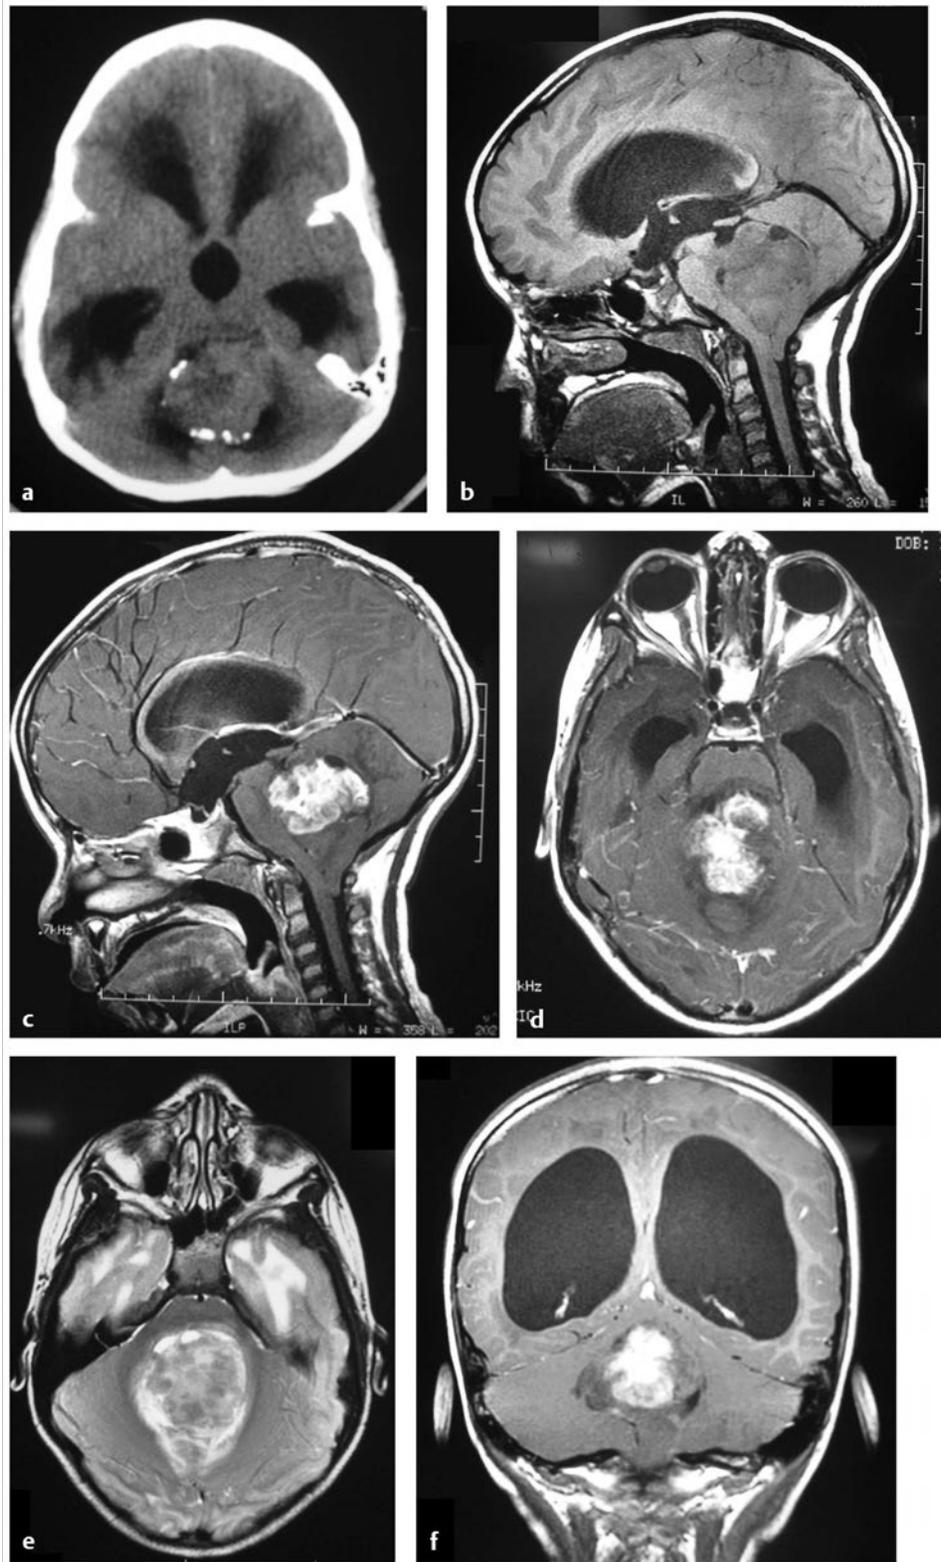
A 5-year-old with headaches and vomiting. (a) An unenhanced computed tomography (CT) scan shows a posterior fossa tumor, with some peripheral calcifications. There is associated supratentorial noncommunicating hydrocephalus from obstruction of the fourth ventricle. (b) Sagittal T1-weighted magnetic resonance (MR) image without intravenous contrast shows a mass lesion in the fourth ventricle that is isointense or hypointense to the brain. Note that the tumor and the cerebellum have protruded down through the foramen magnum. (c) Sagittal T1-weighted MR image with intravenous contrast shows enhancement of the superior portion of the tumor. One of the critical pitfalls in ependymoma surgery is failure to recognize the nonenhancing portion of the tumor. (d) Axial T1-weighted MR image with contrast. (e) Axial T2-weighted MR image shows a high-signal mass lesion in the fourth ventricle. (f) Coronal T1-weighted MR image with contrast shows supratentorial hydrocephalus and the partially enhancing, partially nonenhancing tumor. The nonenhancing portion of the tumor is extending out through the foramen of Magendie.
